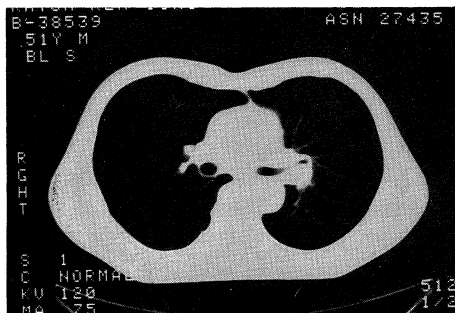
CT scan showing a compression of the bronchus.
